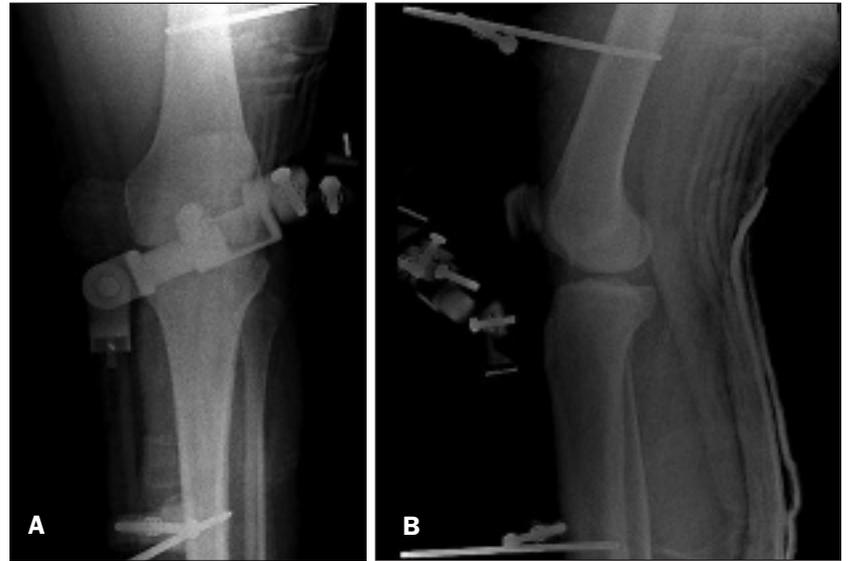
Anteroposterior (A) and lateral (B) views taken during stage 1. These radiographs show the knee reduced with a spanning external fixator.
